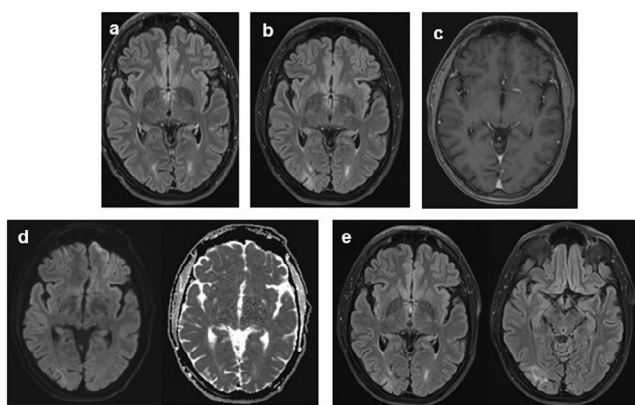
Case 2. Baseline brain MRI (a). Hyperintense right occipital juxtacortical lesion (b), with no contrast enhancement (c) and mild peripheral diffusion restriction on DWI (d). Stability on follow-up MRI (e).
